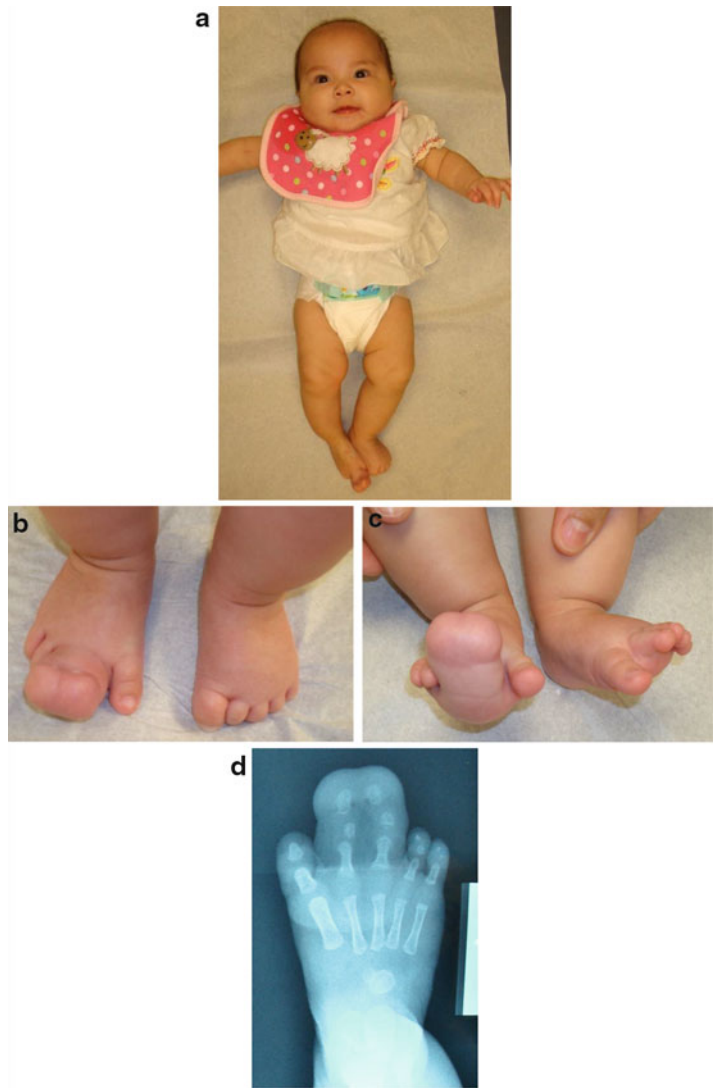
The infant was born with macrodactyly of the right forefoot including the right first toe through third toe with syndactyly between second and third toes. This picture was taken at approximately 7 months of age. At 9 month of age, resection of the first, second, and third ray was performed with debulking of tumorous tissue of the right foot. MRI showed extensive infiltration of the right foot by primarily fatty density tissue extending from the plantar aspect between the toes to the dorsal aspect of the right foot and extending posteriorly and medially into the ankle. This fatty density tissue has soft tissue interspersed within it in swirls. These findings most likely represent fibromatosis
